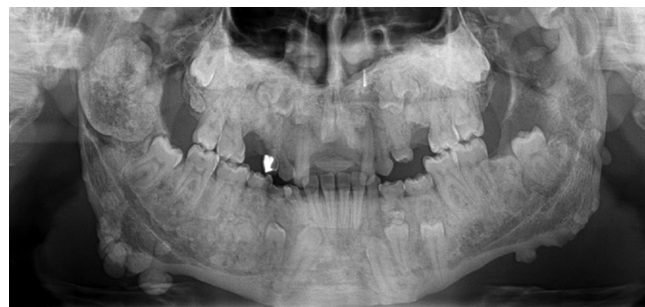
Panoramic x-ray of a patient with Gardner's syndrome
